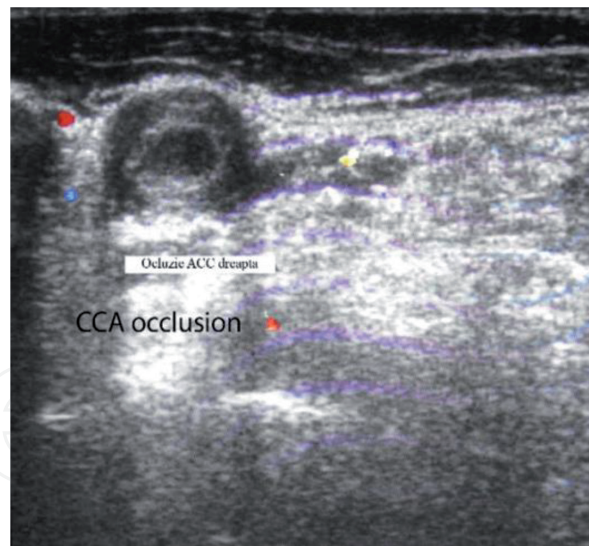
Large vessels GCA, color Doppler ultrasound in transverse view of the right CCA. Hypoechoic wall swelling with right CCA occlusion [9].
